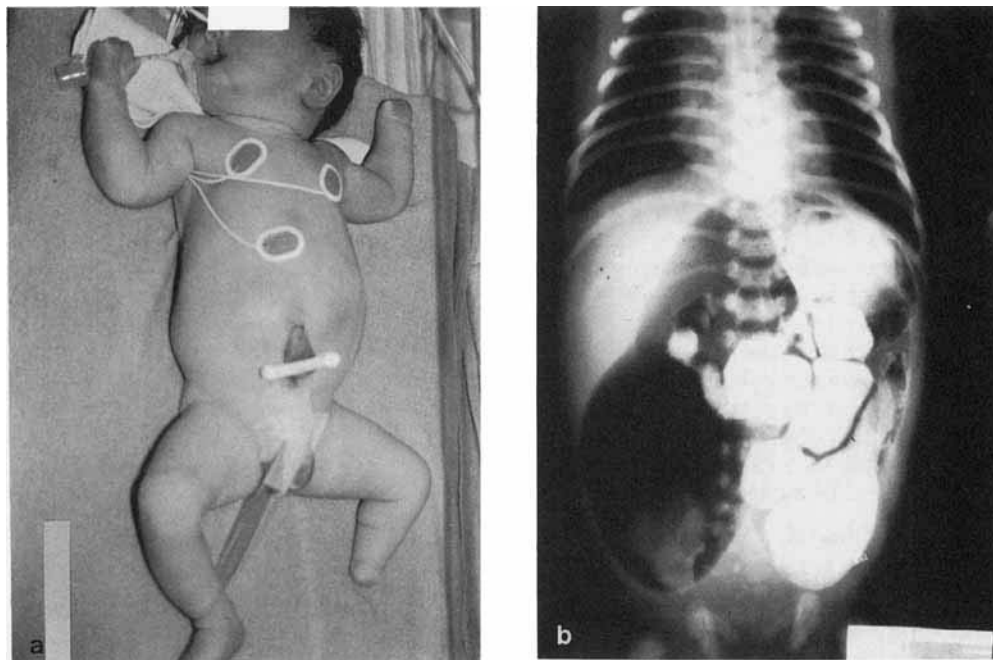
Case 1: (a) oromandibular-limb hypogenesis anomaly with cleft lip; (b) radiograph of the intestine showing jejunal atresia.
